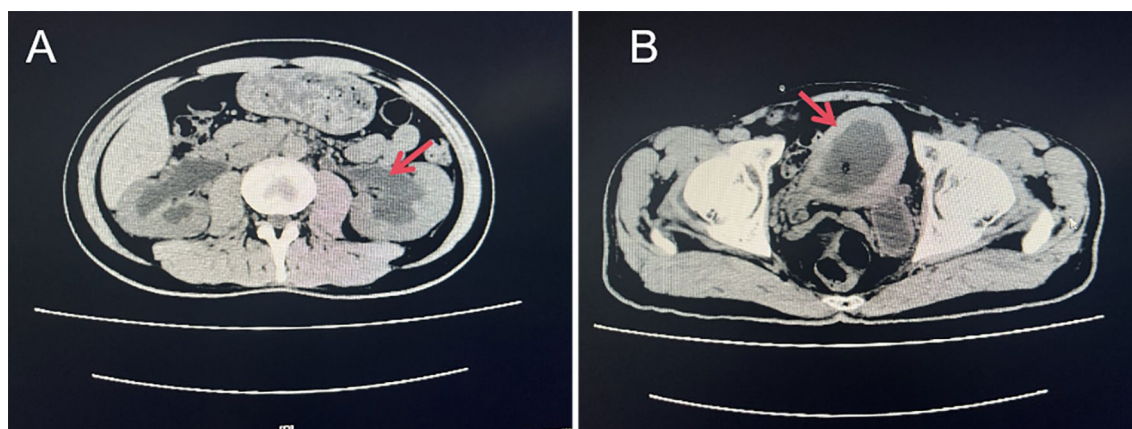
Pretreatment CT-Abdomen demonstrating hydronephrosis in both kidneys and the bilateral ureters (A) and bladder wall thickening and bladder capacity reduction (B)
